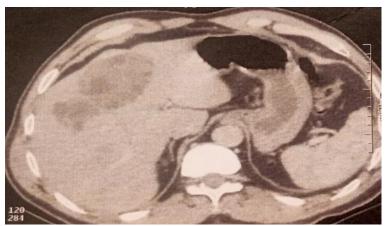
Abdominal CT scan showing a cystic formation with heterogeneous contentevoking a LHC OF TYPE IV straddling segment V and VI without dilation of BD.
